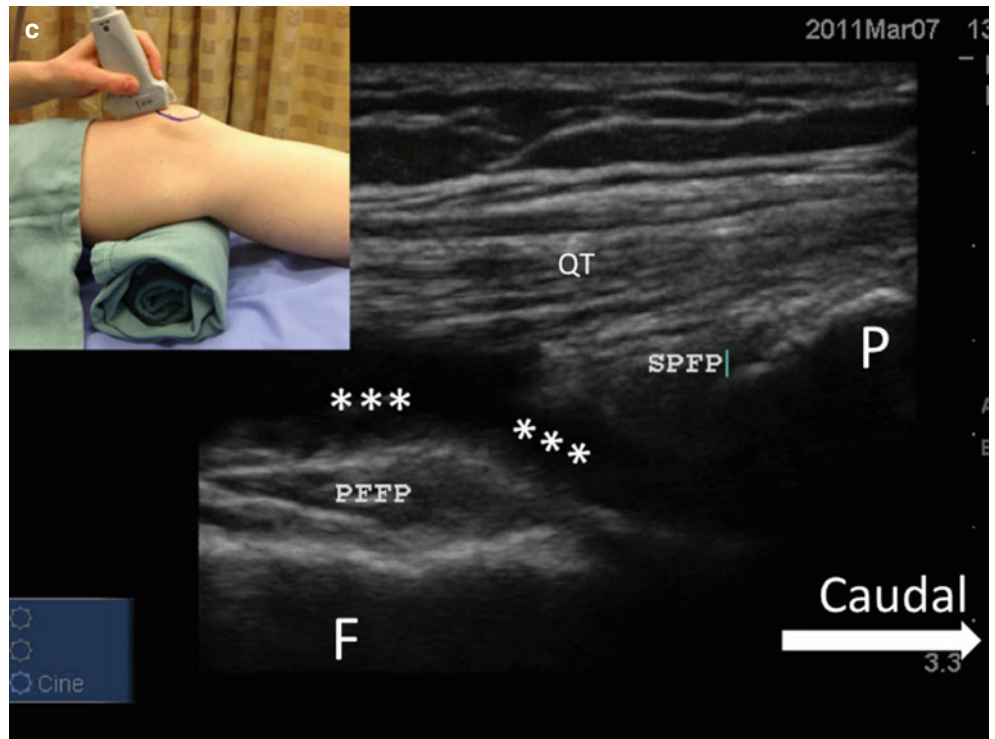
(a–c) (a) Sonogram of the suprapatellar view of the normal knee. The insert showed the position of the patient and the ultrasound probe. (b) Sonogram of the details of quadriceps tendon (*QT*). (c) Sonogram of the suprapatellar view of a patient with knee effusion. Note the presence of effusion fluid filling the space between prefemoral fat pad and quadriceps tendon. *SPFP* suprapatellar fat pad, *PFFP* prefemoral fat pad, *P* patella, *F* femur,  indicates the suprapatellar recess (Reproduced with permission from Dr. Philip Peng from Philip Peng Educational Series)
